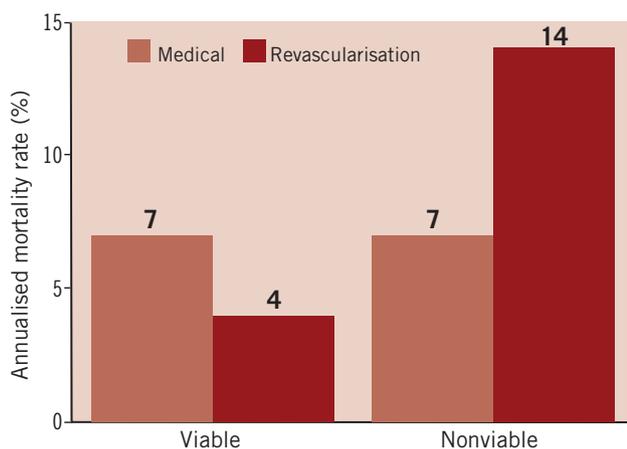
Pooled analysis of data from eight studies using ²⁰¹Tl SPECT for assessment of long-term survival. Annualised mortality rates in patients with viable and nonviable myocardium in relation to treatment (revascularisation or medical therapy). Figure based on reference 3.
